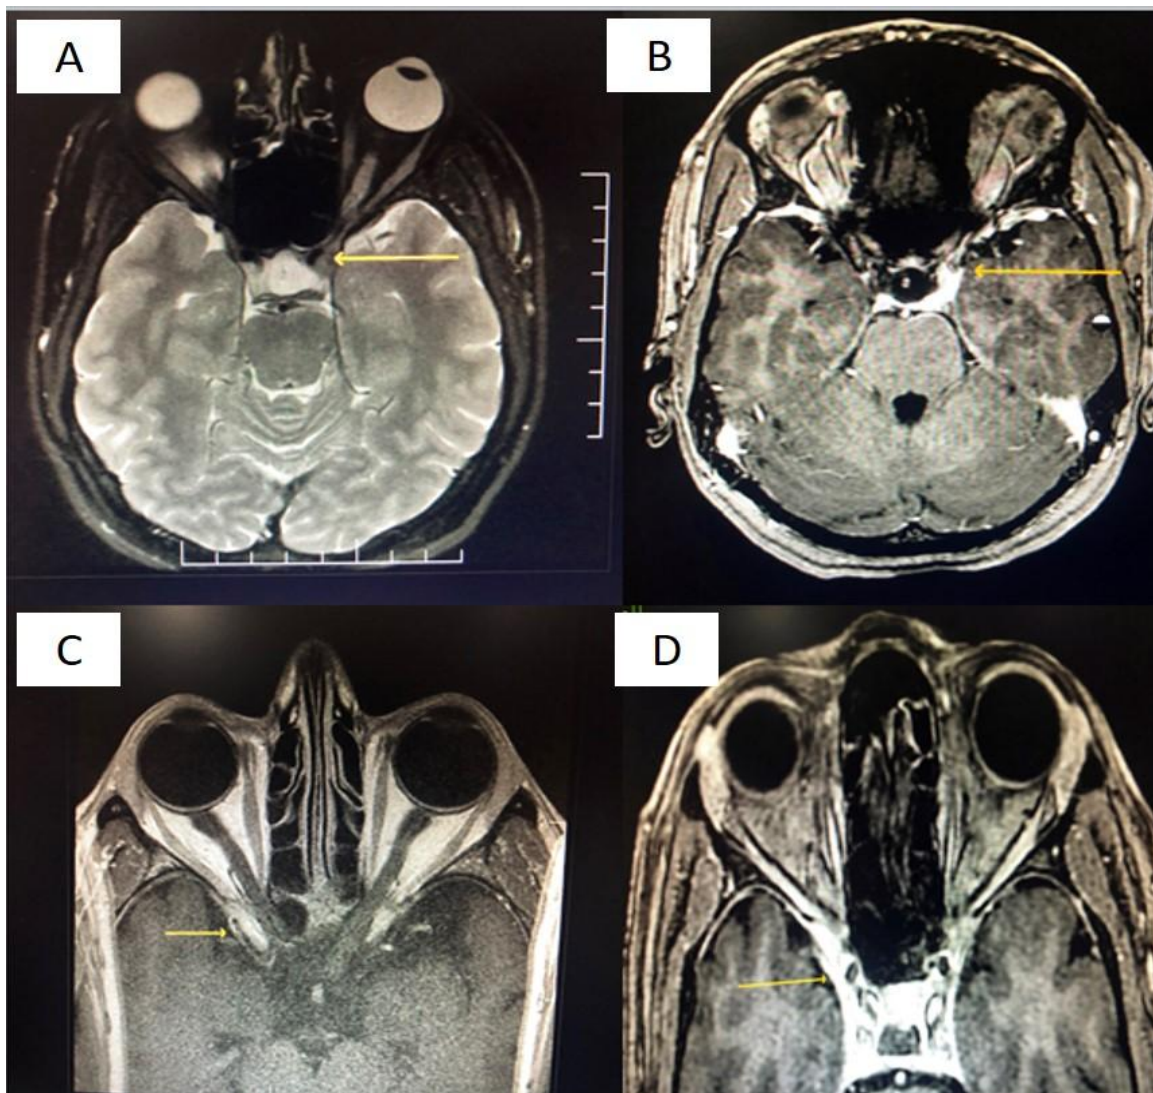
MRI showing abnormalities in SOFS. A) Abnormal soft tissue seen involving left cavernous sinus encasing the cavernosal segment of ICA causing narrowing of the ICA. B) Post contrast enhancement of the soft tissue seen extending up to the left orbital apex. C) Homogenous signal intensity along the right orbital apex and superior orbital fissure. D) Post contrast enhancement noted
